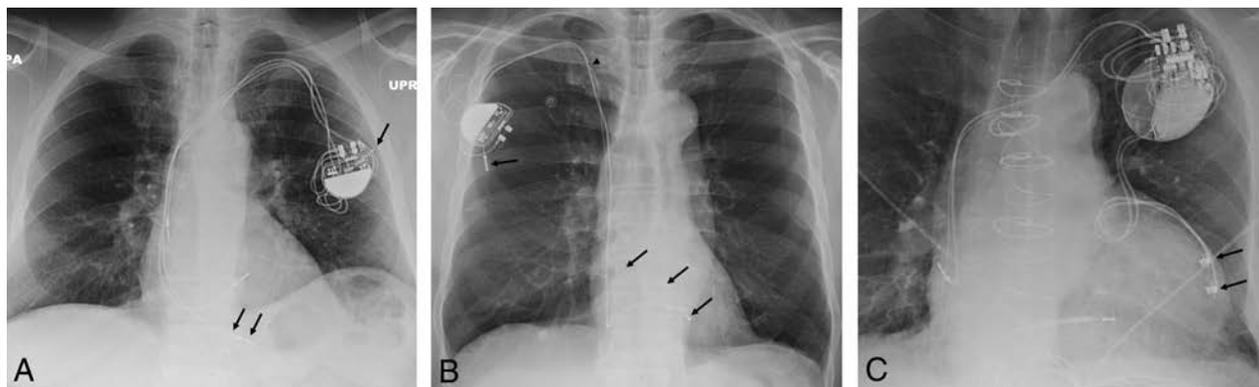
Absolute contraindications: chest x-ray examinations with abandoned and epicardial leads. Posteroanterior view of the chest (A) demonstrates an abandoned lead (black arrows) in a patient with a dual-chamber pacemaker device. B, An abandoned right ventricular lead (black arrows) in a patient with a single-lead pacemaker device. The black arrowhead denotes a fracture of the abandoned lead. C, A patient with a biventricular ICD pacing system, which includes transvenous atrial and right ventricular leads and 2 permanent epicardial pacing leads (black arrows). None of these 3 patients would be cleared to undergo MR imaging examination at our institution.
